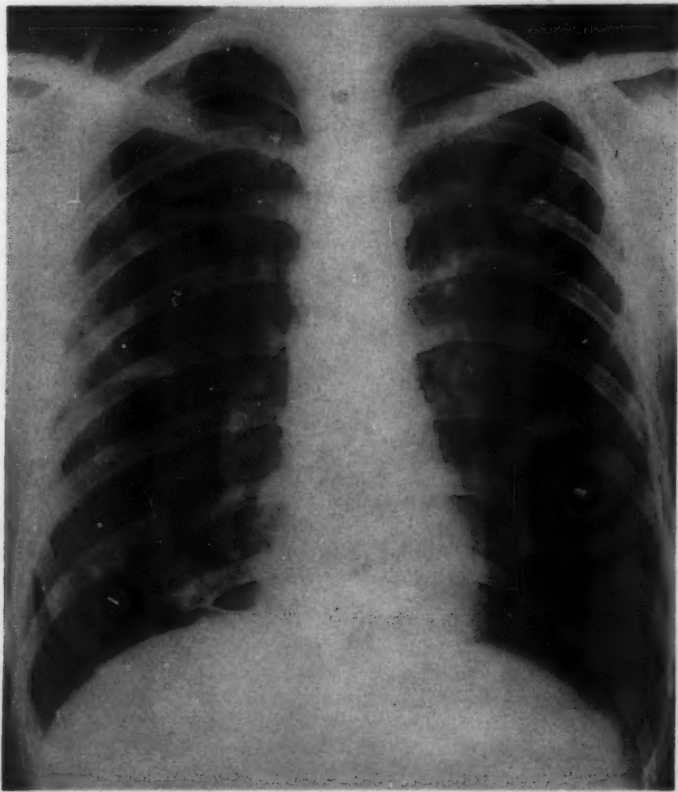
Chest x-ray following courses of chloroquine and emetine, revealing a diminution of nodularities and pneumothorax.
